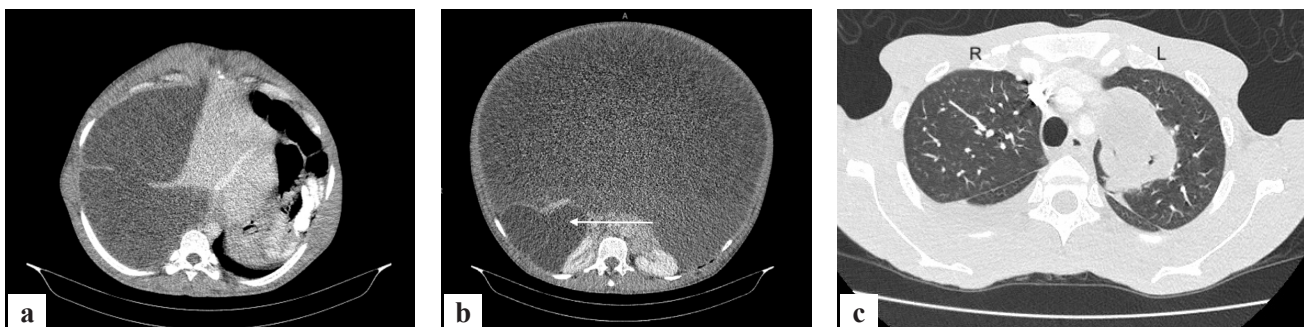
Contrast-enhanced CT images of a) liver cysts, b) massive abdominal distension due to thin-walled daughter cysts filling the peritoneal cavity, c) an 8 cm hydatid cyst in the left upper lung lobe
